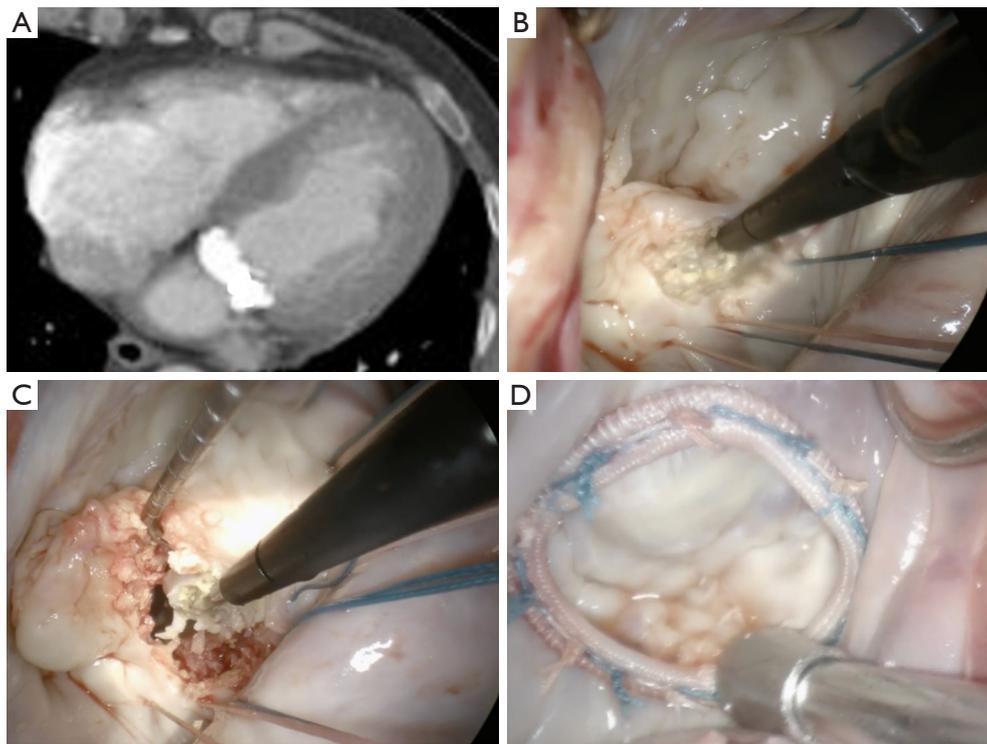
Preoperative image. (A) Axial CT scan demonstrating severe posterior MAC. Intraoperative images. (B,C) Decalcification of the posterior leaflet and annulus using Sonopet device. (D) Mitral valve repair and final saline test with annuloplasty ring. CT, computed tomography; MAC, mitral annular calcification.
